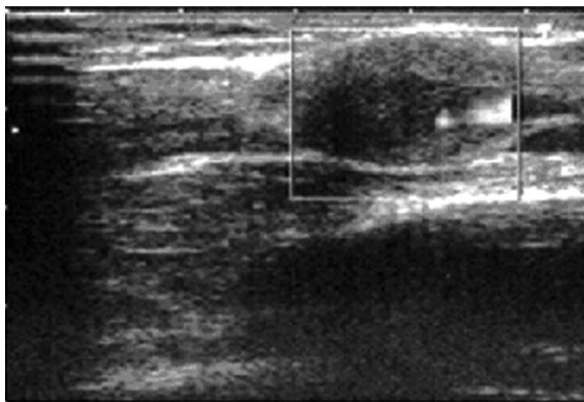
B-mode ultrasound of brachial artery. This longitudinal view demonstrates a dilated lumen with a surrounding mass giving the appearance of an aneurysm. Angiolymphoid hyperplasia with eosinophilia arising from brachial artery.
